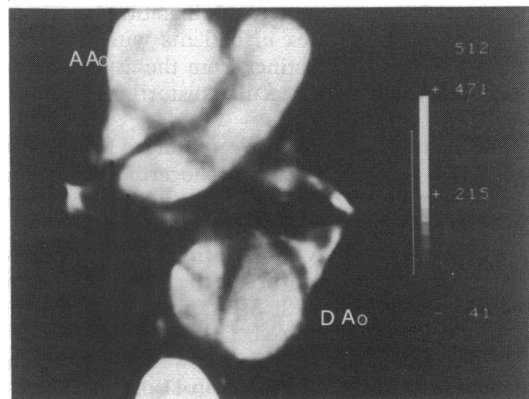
Contrast enhanced computed tomograph in case 30, showing type I aortic dissection. This lesion was not detected by echocardiography. AAo, ascending aorta; DAo, descending aorta.
